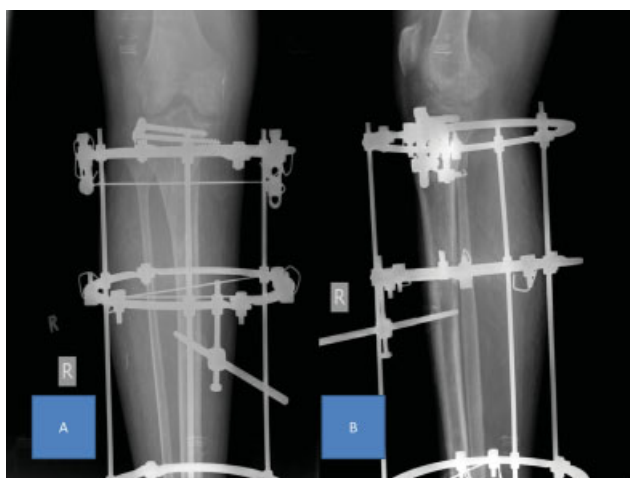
and 7B Anteroposterior and lateral radiographs of Patient 13 in the immediate postoperative period, with ring fixation.
